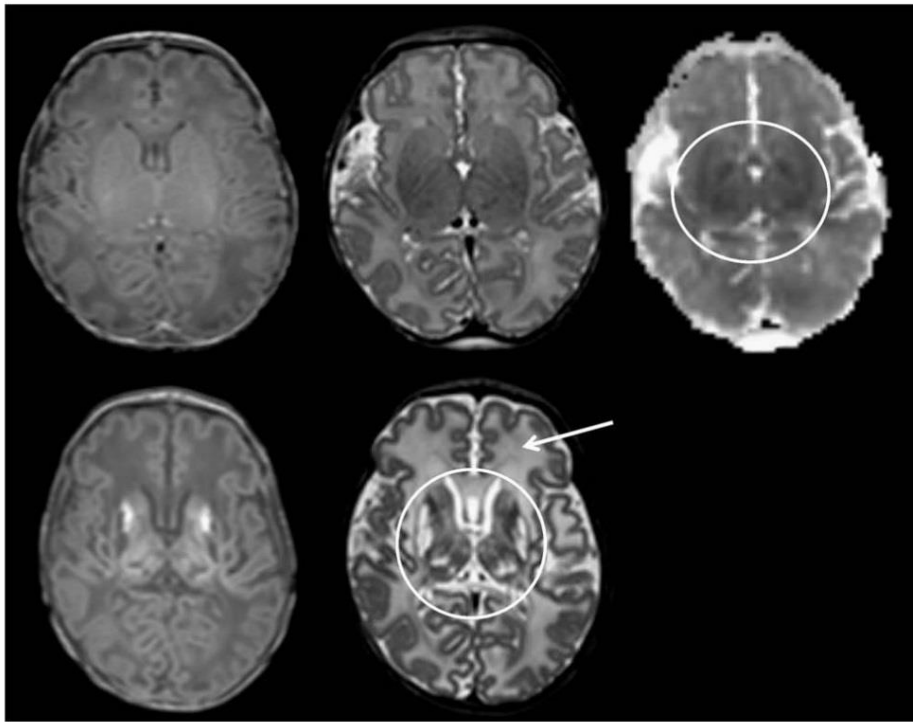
Different MRI modalities for assessing perinatal HIE. This image was published by Rutherford et al. (30) with the following legend: Diffusion-weighted imaging in the basal ganglia and thalami. Top row. T1 (left) and T2 (middle) weighted images and ADC map (right) acquired on day 3. The ADC map shows several regions of abnormal low signal intensity within the basal ganglia and thalami (BGT) that look relatively subtle (circular region of interest). Bottom row. Day 22. T1 (left) and T2 (right) weighted images. The BGT abnormalities are very severe with no normal looking tissue within the BGT (circular region of interest). Any abnormality within the BGT on an early ADC map is likely to be clinically significant and any one diffusion-weighted examination is likely to underestimate the final lesion load. By day 22 the white matter signal intensity (arrow) has become abnormally high and there has been no head growth in this neonate.
